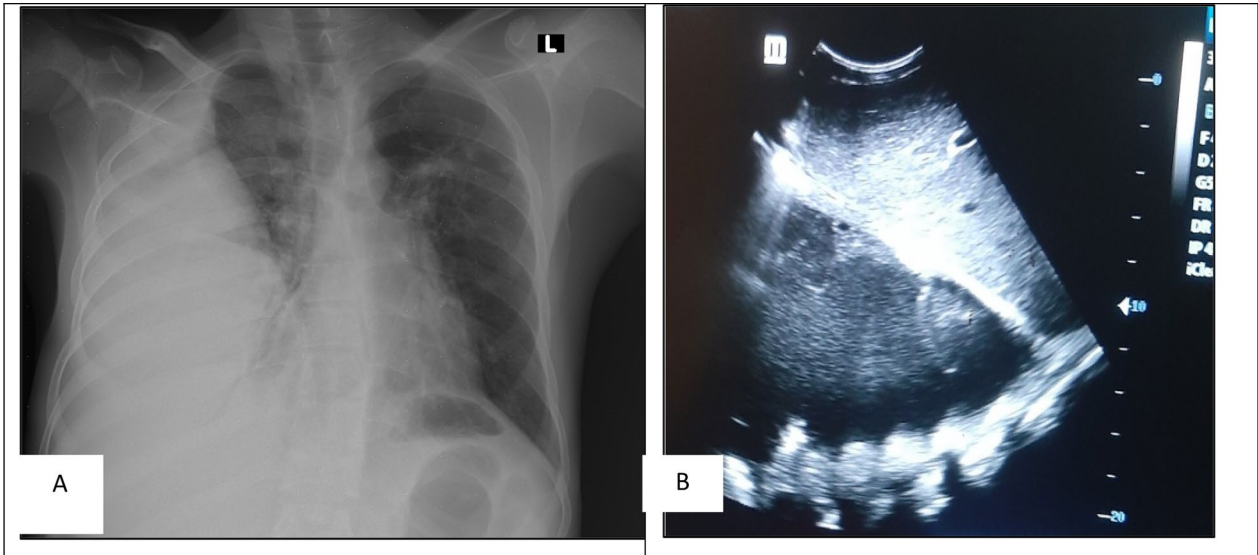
Posteroanterior chest X-ray showing right sided biconvex homogeneous pleural-based opacity compressing the entire right lung with a mediastinal shift to the left (A) and (B) bedside chest ultrasound showing a retro-hepatic and supra diaphragmatic fluid collection with echo-debris content
